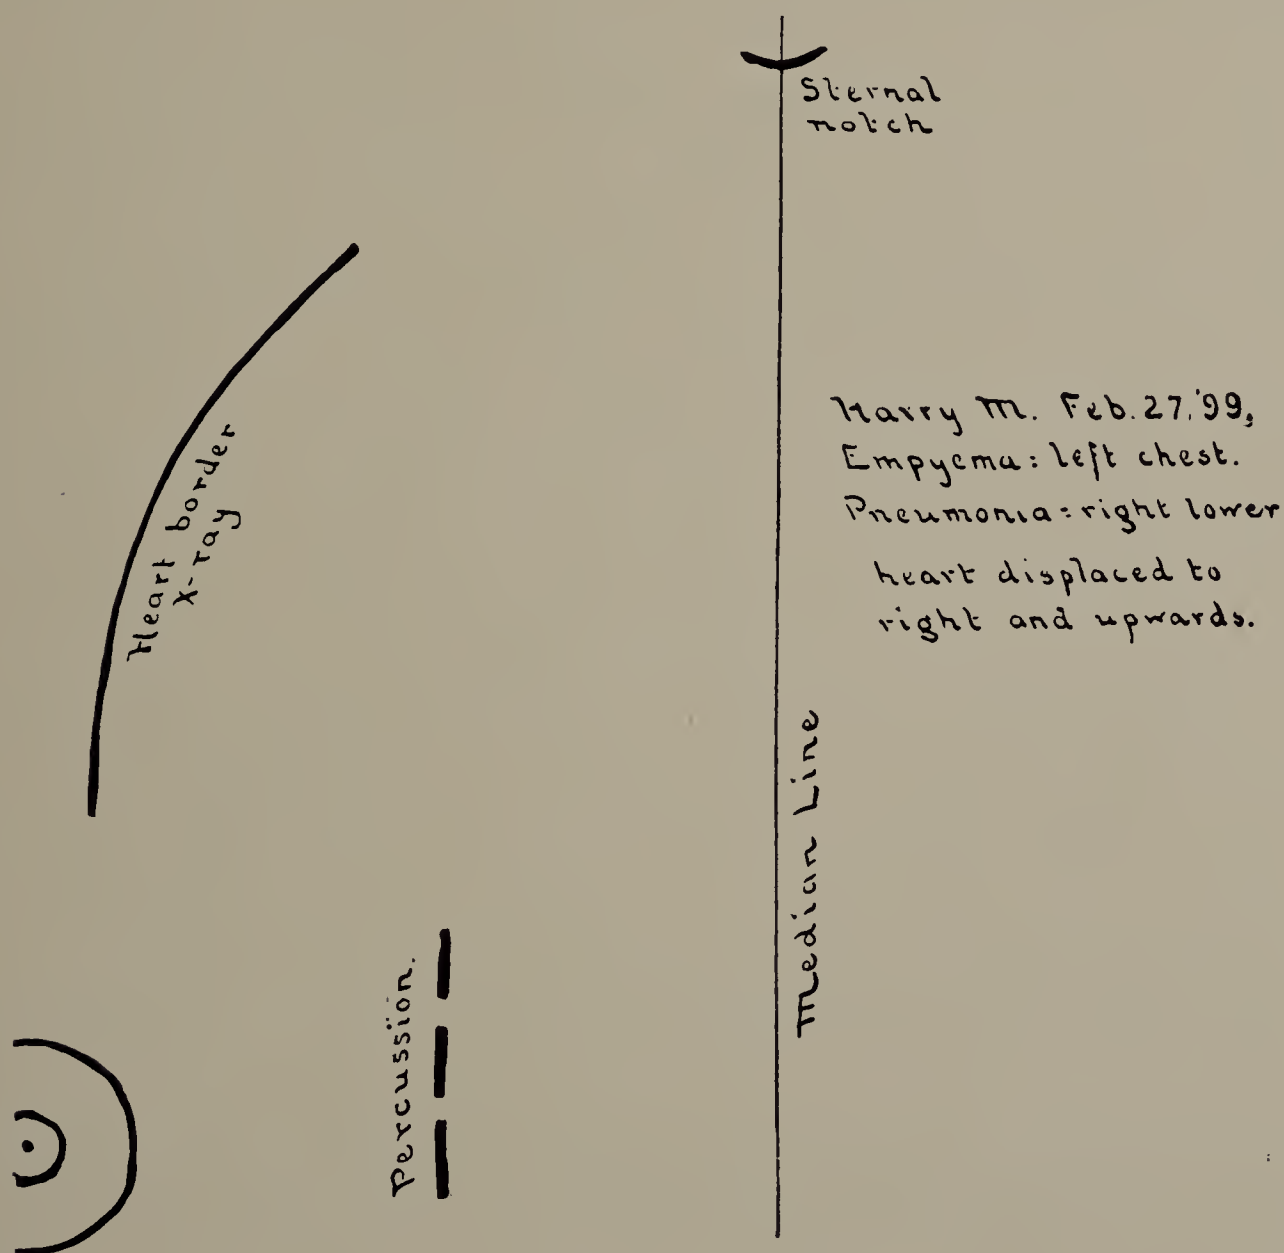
Harry M. February 27, 1899. X-ray tracing. Full line shows the position of the right border of the heart; broken line shows its position as determined by percussion. (Cut one-third life size.)
